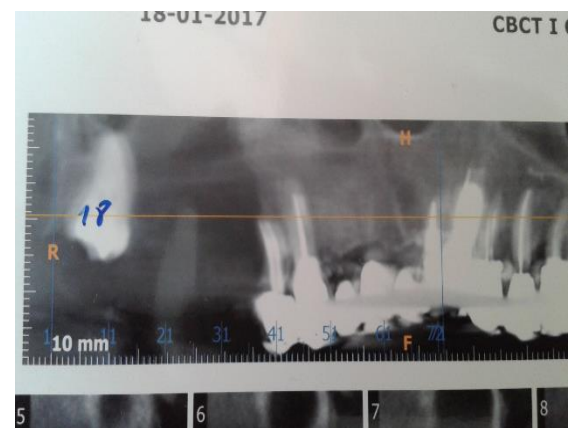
Panorex Tc cone beam showing maxillary Osteolytic lesion of the jaw
